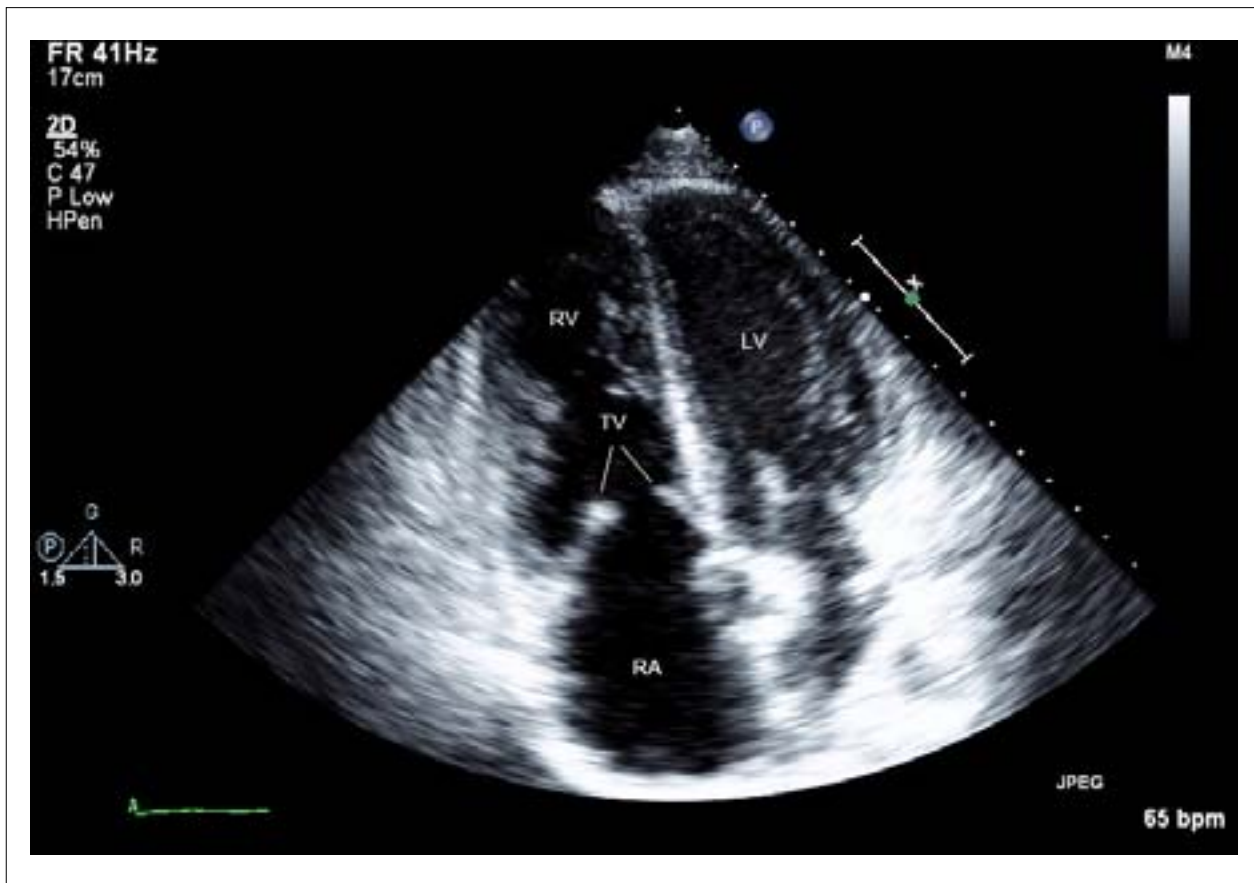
Apical four chamber view showing thickened, retracted and completely non-mobile tricuspid valve leaflets.
